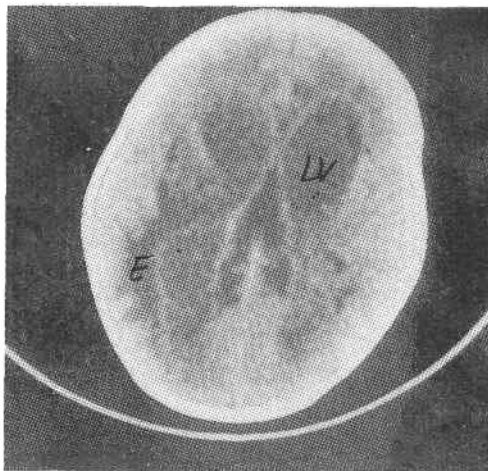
Axial CT scan showing dilated lateral ventricles (LV) with enhancing walls and periventricular edema (E).
